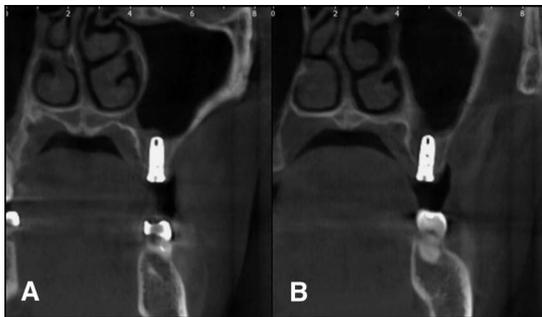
CBCT was taken at impression taking for provisionals, demonstrating newly formed bone above the implant apices. Bone consolidation was observed on (A) the right first molar area and (B) the right second molar area.
